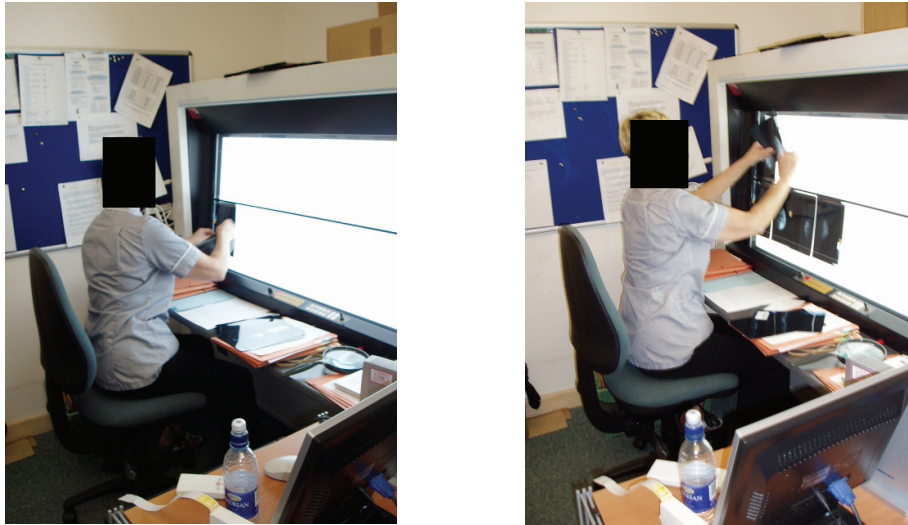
X-ray films being mounted onto a multiviewer.
